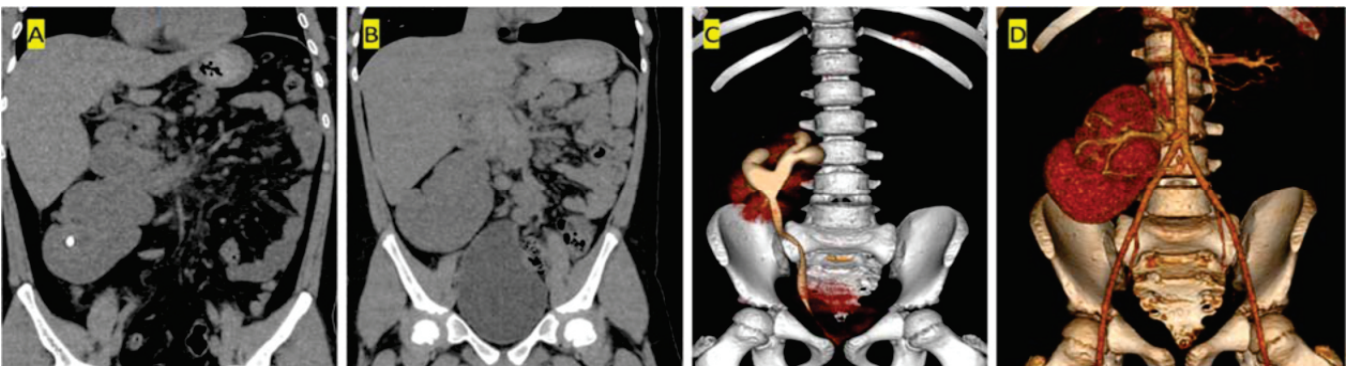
Crossed fused renal ectopia. A: Fused renal tissue in right iliac fossa, calculus in lower moiety. B: Right cross fused ectopia with overdistended urinary bladder. C: Excretory image showing single draining ureter. D: CT Angio showing low lying right renal artery and accessory renal artery from left common iliac artery.
